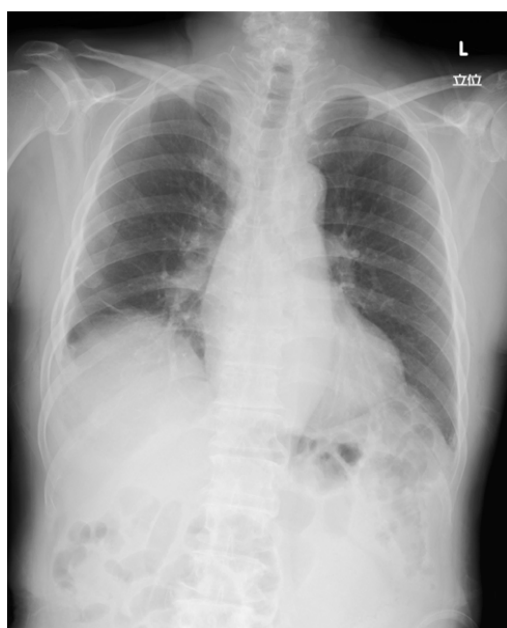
Chest radiograph on the seventh postoperative day.
